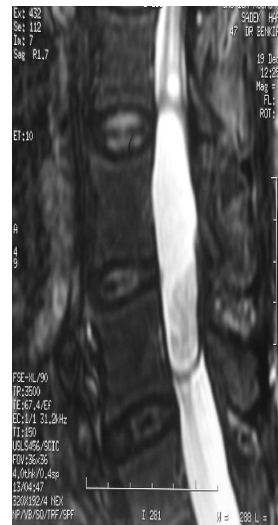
→ T2 MRI: showing the importance of the cystic component.
